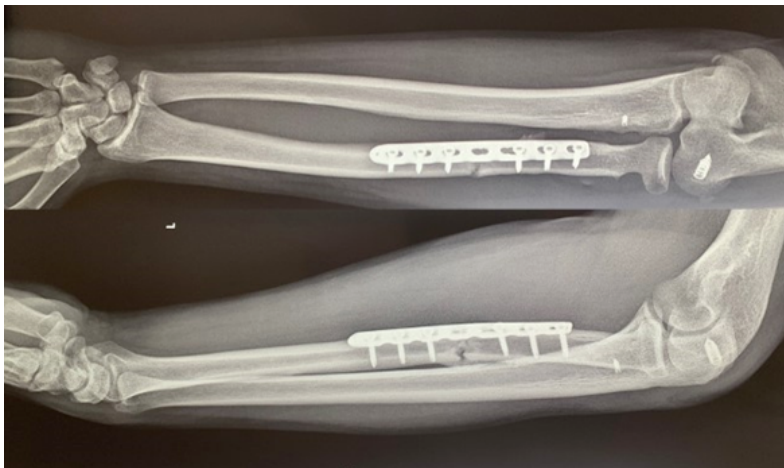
One month post-operative x-ray control of the left forearm.
